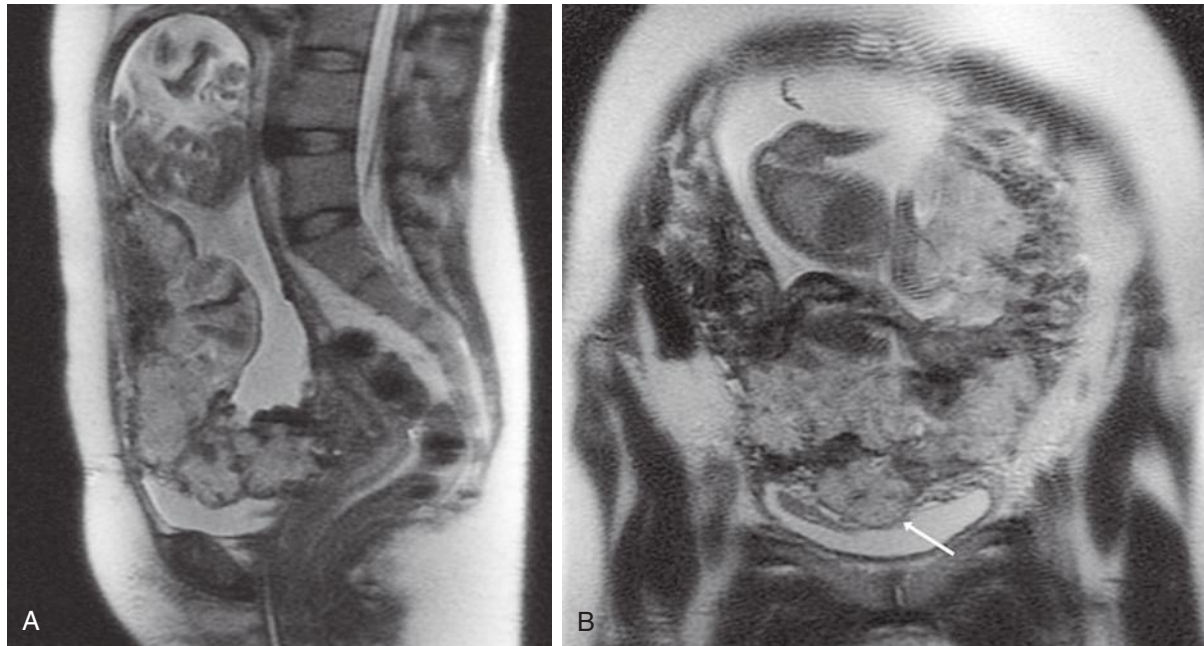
Placenta percreta. Placental invasion with involvement of the maternal bladder wall, indicating placenta percreta, is shown on these sagittal (A) and coronal (B) single shot fast spin echo magnetic resonance images, obtained for purposes of surgical planning. The heterogeneity of the placenta is due to lacunae. Irregularity of the placental interface is noted with extension into the bladder wall (arrow). Intraluminal material within the bladder represents blood clot. (Courtesy of Dr. Liina Poder, University of Texas Southwestern Medical Center, Dallas, Texas.)
